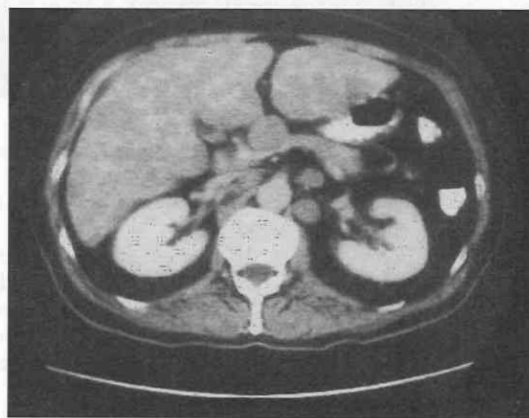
Diffuse infiltrative lymphoma. Contrast-enhanced CT scan demonstrates diffuse involvement of the liver. Lymphadenopathy is present.
